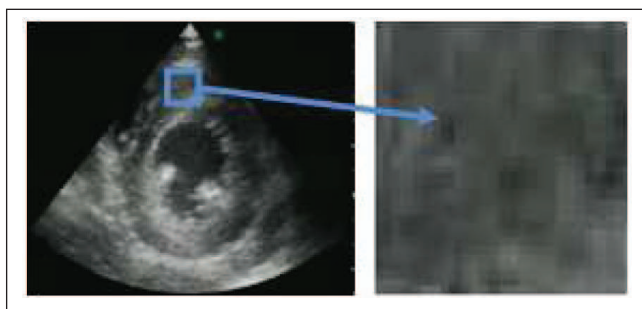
Encircled homogeneous region (left) in echocardiogram and enlarged region (right) with speckle pattern typical in ultrasound images.
